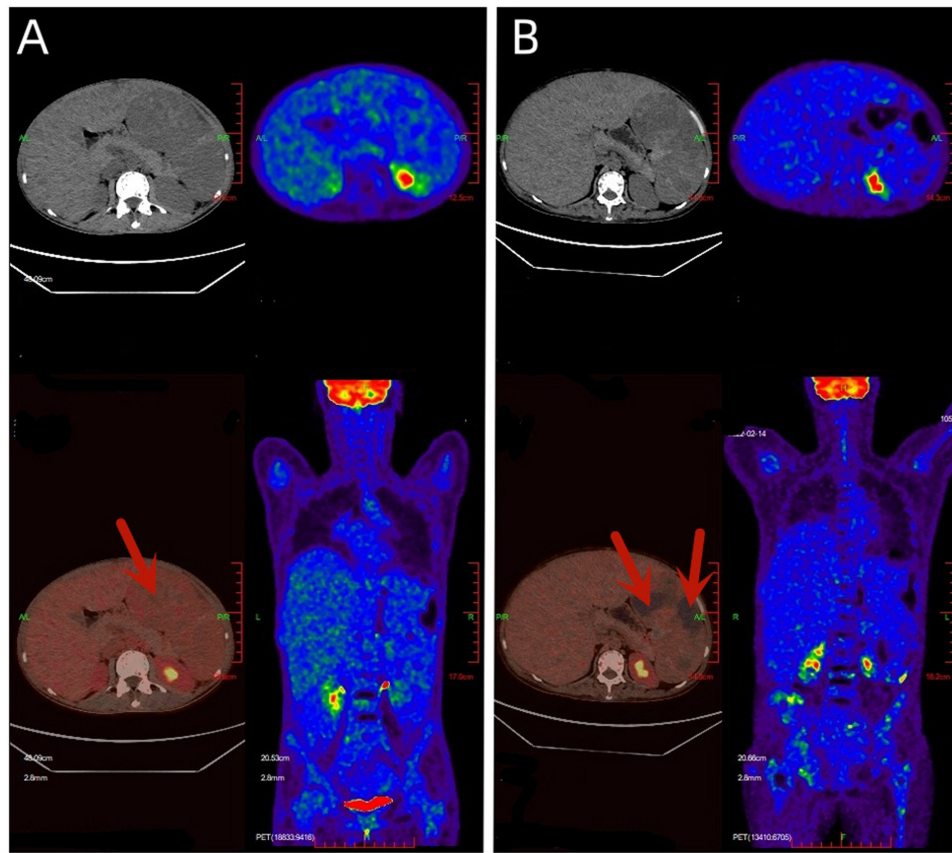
The images in the upper panels represent CT scans, and the images in the lower panels exhibit the fusion of PET and CT. The volume of the spleen increases and multiple necrotic areas without glucose uptake are observed (red arrows). (A) PET/CT performed on September, 2021 revealed maximum cross-section of the spleen was 146x109 mm, with upper and lower diameters of 275 mm, and an SUVmax of 4.7. (B) A PET/CT scan performed on February, 2022 showed maximum cross-section of the spleen was 164x112 mm, with an upper and lower diameter of ~283 mm, and an SUVmax of 6.3. PET, positron emission tomography; CT, computed tomography; SUVmax, maximum standard unit value.
